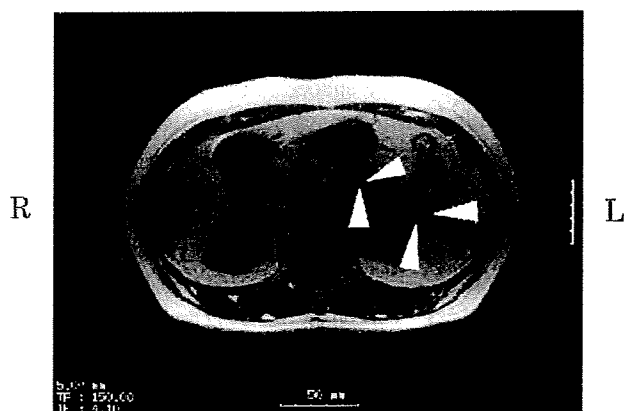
Abdominal MR imaging showed nodules in the pancreas (diameter 5 mm in body [center arrowhead], 25 mm in tail [end arrowhead]), suggesting the presence of pancreatic islet tumors.
